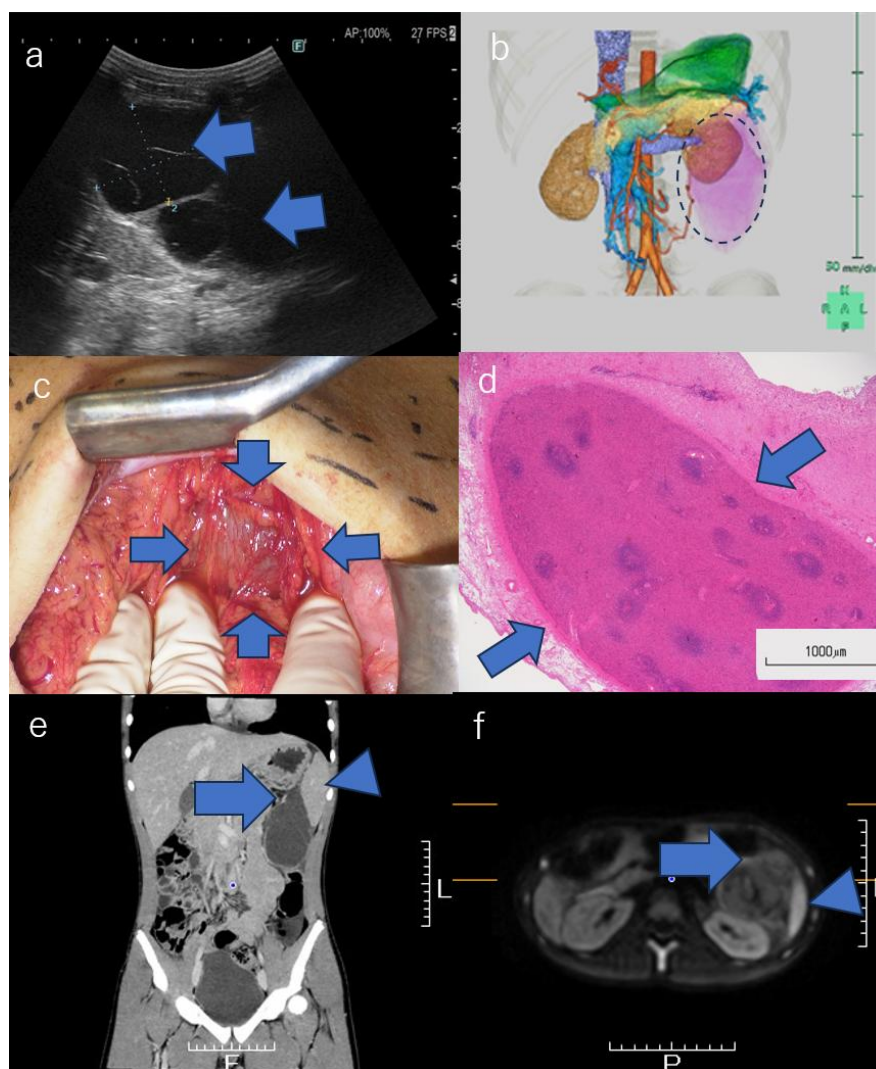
(a) Ultrasound findings show two main large cystic masses (arrow) with internal septa that were observed in the left flank area, measuring approximately 13 cm in maximum overall diameter; (b) Three-dimensional Computed Tomography (CT) shows the cysts (dotted lines) in contact with the tail of the pancreas, the spleen, the splenic flexure of the colon and the kidney; (c) Operative findings: The visualization of the gastric omentum revealed a potential tumor (arrow) at the head of the transverse colon; (d) Pathological findings: The cyst wall had a thick fibrous wall and the epithelium of the lumen was not clear. Splenic tissue (arrow) was observed within the cyst wall. Bar size is 1000 μm ; (e) Coronal contrast CT shows small mural nodules (arrow) in the cyst wall, which were of the same density as the spleen (arrowhead); (f) MRI shows high signals in the mural nodules (arrow) on diffusion-weighted imaging, which have the same density as the spleen (arrowhead).
